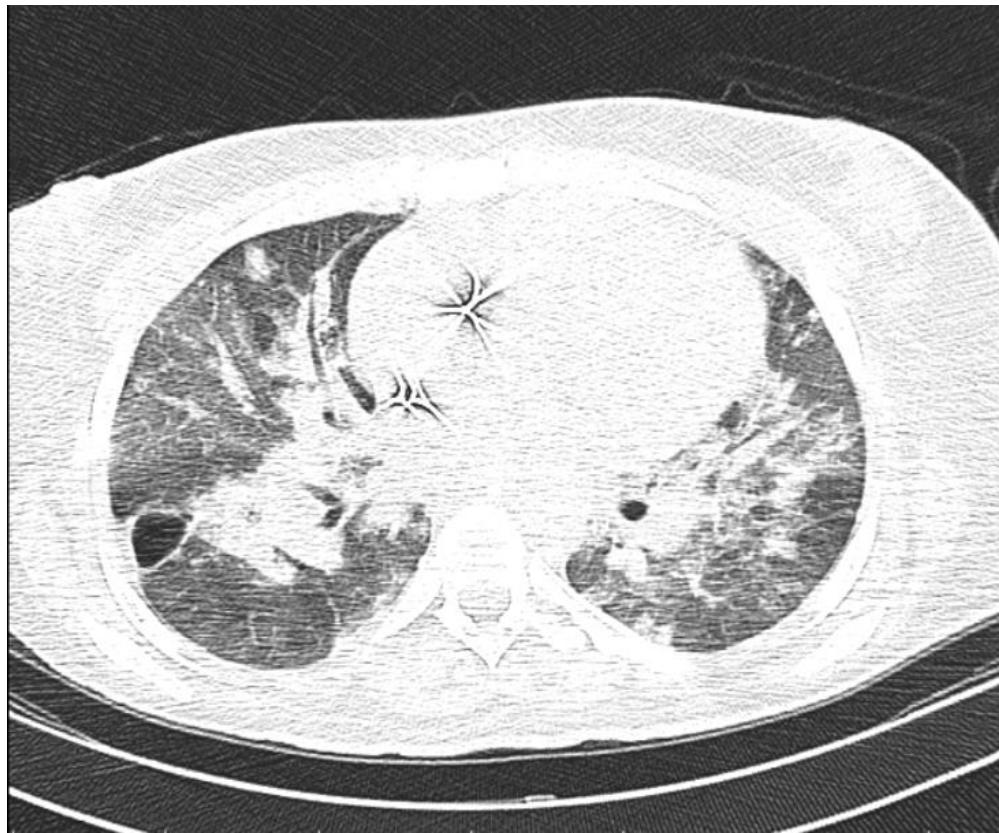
The patient's spiral lung high-resolution computed tomography shows multiple ground-glass opacities, perifissural consolidation at the right upper lobe, and consolidation with cystic bronchiectasis at the posterior and lateral segments of the right lower lobe.
